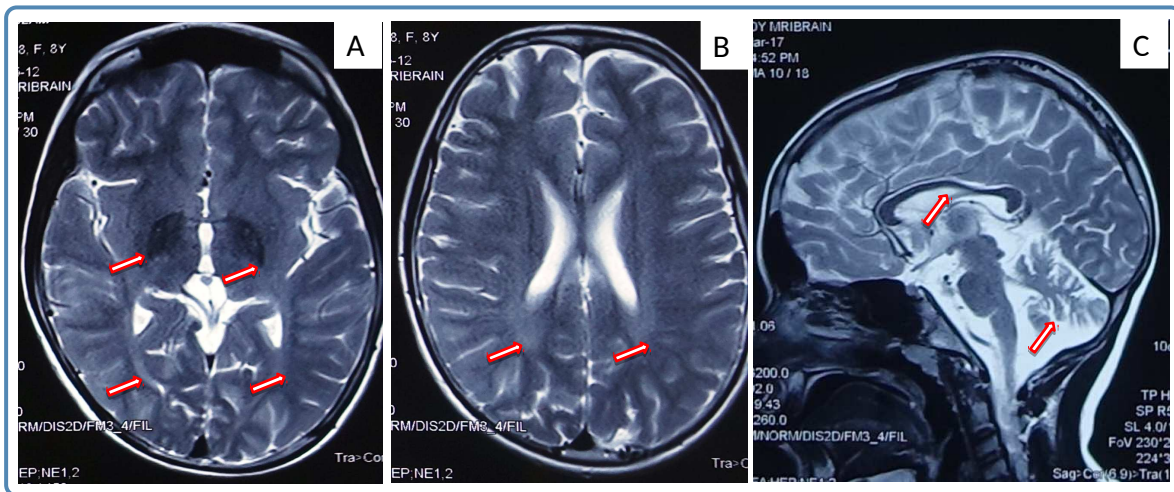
MRI of the brain (T2 images) showing hypointensity in bilateral globus pallidus (Fig 1A), white matter hyperintensities (Fig 1A & 1B), thin corpus callosum and cerebellar hypoplasia (Fig 1C). Figures A & B axial view, figure C) sagittal view.
